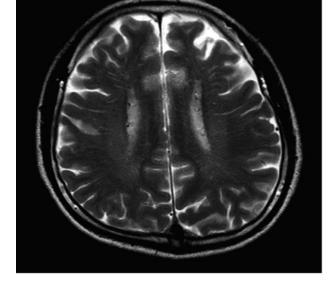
Axial magnetic resonance images using (a & b) T1-weighting and (c & d) T2-weighting, showing multiple small, hypointense dots around the periventricular and basal ganglia regions, indicating moyamoya disease associated collateral vessels.
